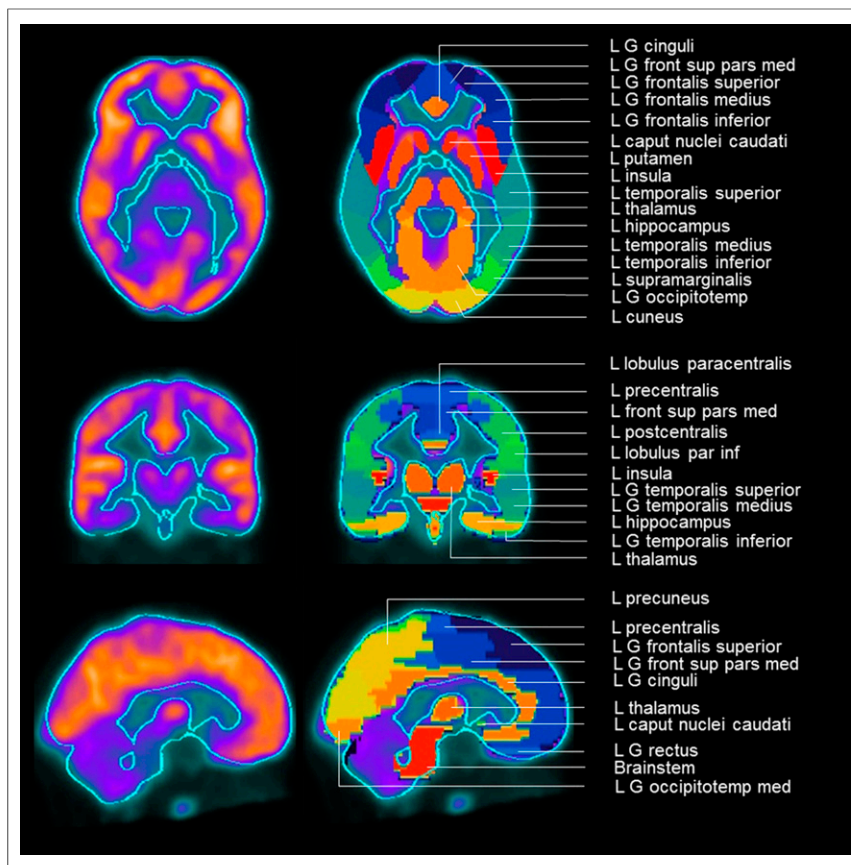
Spatially normalized ^{18}F -FDG PET (left) and region-of-interest overlays (right) of example patient. front = frontalis; G = gyrus; inf = inferior; med = medial; occipitotemp = occipitotemporalis; par = parietalis; sup = superior.
